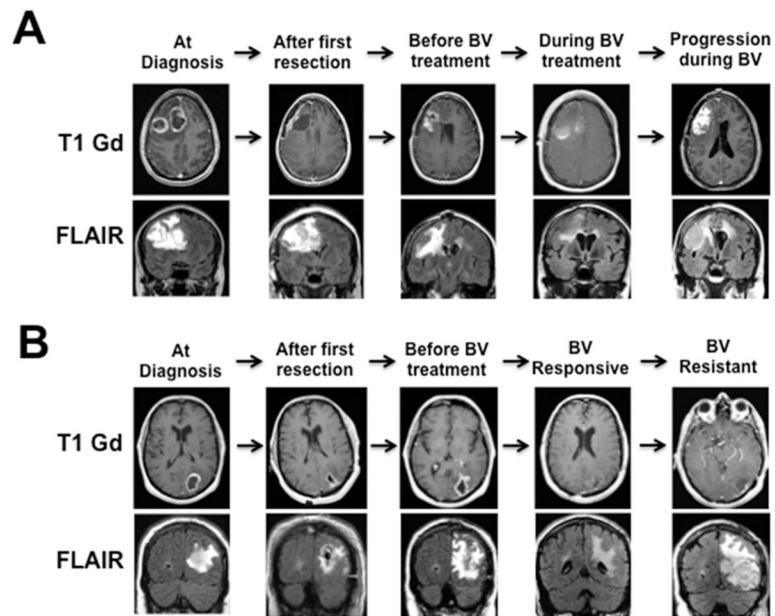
Axial (*upper row*) and coronal (*lower row*) MRI findings associated with progression during bevacizumab (BV) treatment. Shown are examples of (A) enhancing and (B) nonenhancing progression occurring during bevacizumab treatment. T1 = T1-weighted.
